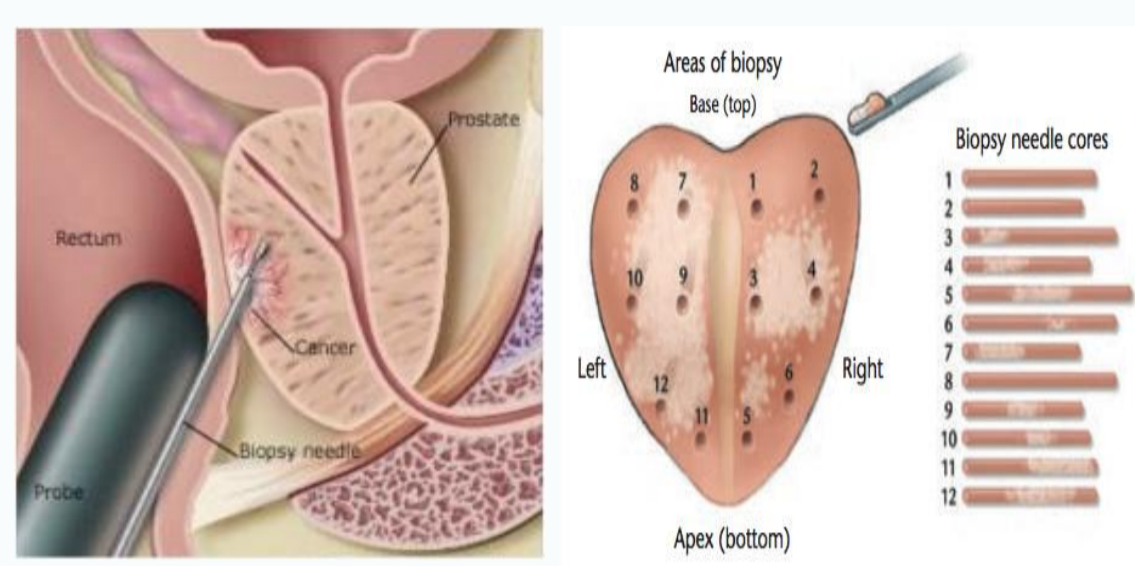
Transrectal ultrasound guided biopsy scheme.
